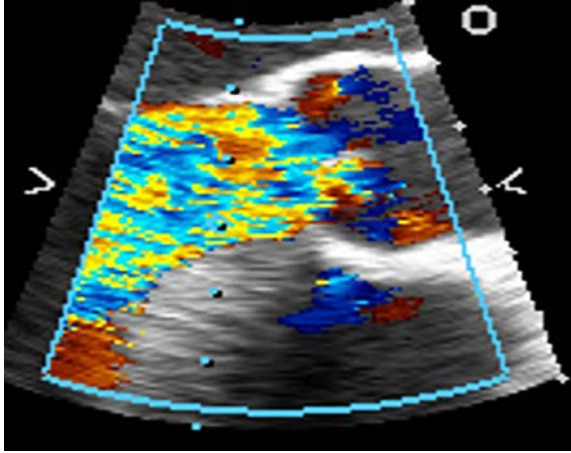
Parasternal long axis view of the aortic valve with colour Doppler indicating severe aortic insufficiency.
